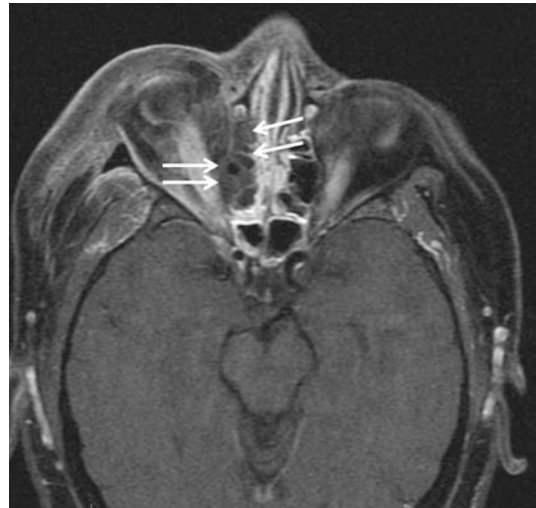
MRI of the head of the patient in Fig. 15.1. There is hypodense material within the right nasal passage concerning for necrotic tissue. There is destruction of the medial wall of the right orbit
